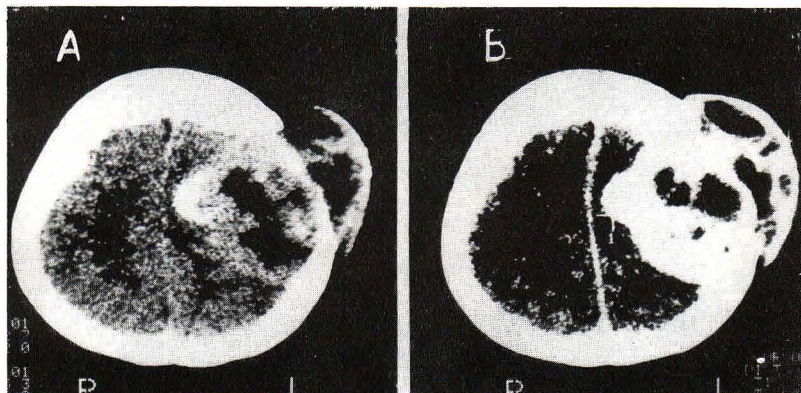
A. Plain CT scan of skull and brain shows a large mass with non-homogeneous high and low densities destroying the cranial vault and extending extracranially at the left parietal region. B. Dense enhancement is exhibited at the area of high density of the lesion on enhanced CT scan.
